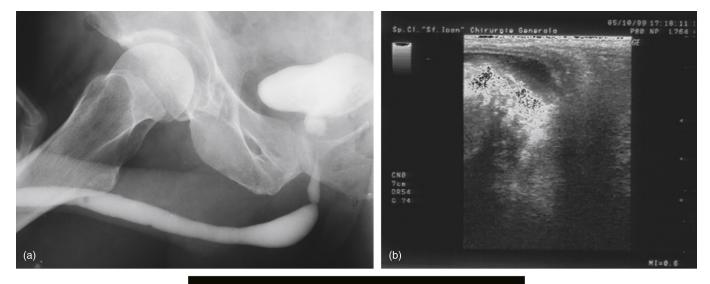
Comparison between aspects of a stricture of the bulbar urethra explored by (a) urethrography, (b) ultrasound (showing also the extension of spongiofibrosis), and (c) endoscopy.
